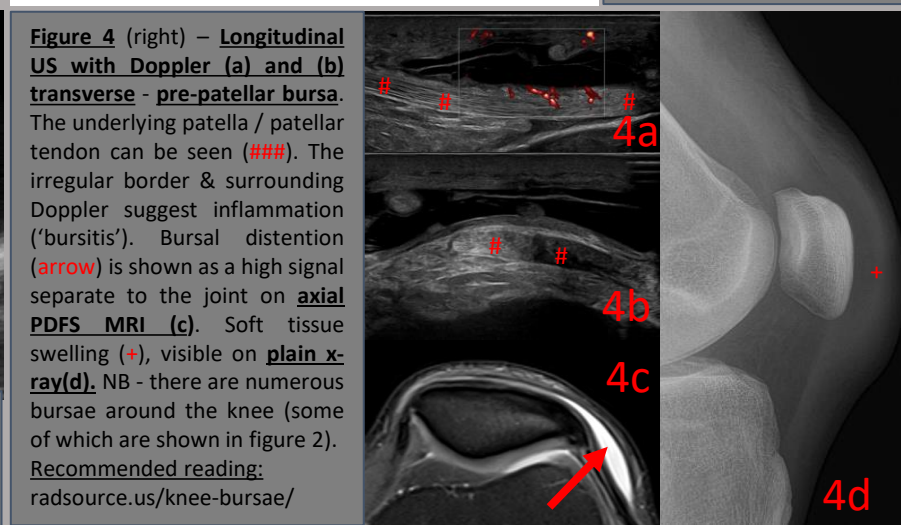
(right) - Longitudinal US with Doppler (a) and (b) transverse - pre-patellar bursa. The underlying patella / patellar tendon can be seen (###). The irregular border & surrounding Doppler suggest inflammation ('bursitis'). Bursal distention (arrow) is shown as a high signal separate to the joint on axial PDFS MRI (c). Soft tissue swelling (+), visible on plain x-ray(d). NB - there are numerous bursae around the knee (some of which are shown in figure 2). Recommended reading: radsourc.us/knee-bursae/
